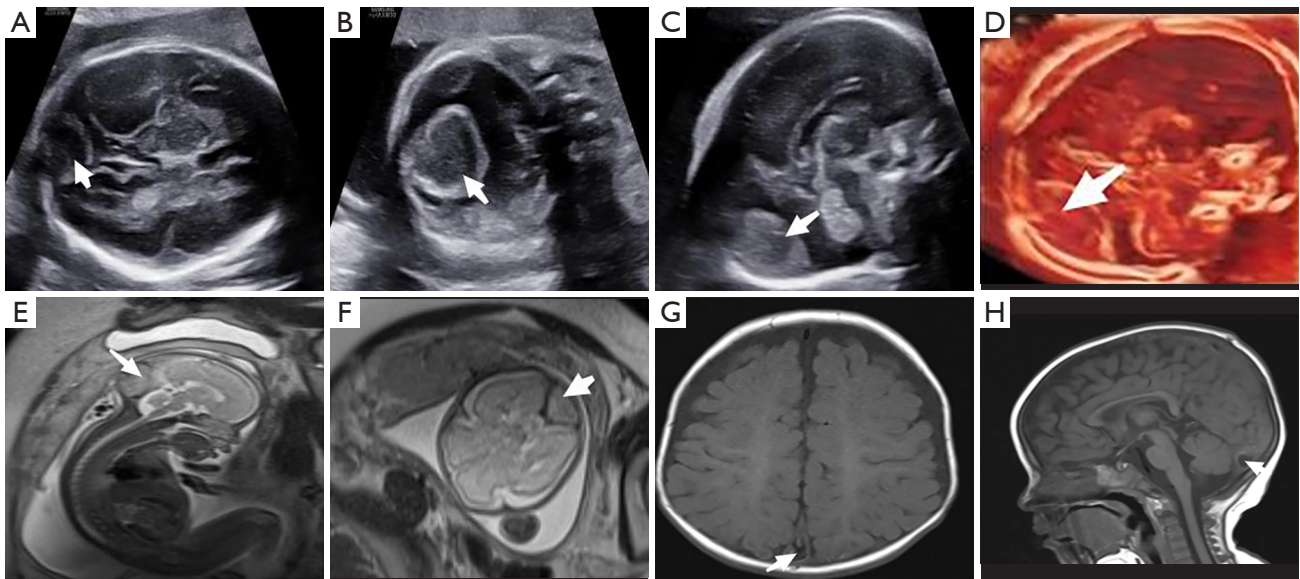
Prenatal ultrasound and prenatal and postnatal MRI images. (A) 2D ultrasound transverse view of the brain shows cystic anechoic at the confluence of the sinus (white arrow). (B) Sagittal view of the skull shows fetal sagittal sinus widening and its internal thrombus (white arrow). (C) Coronal view of the brain shows the thrombus at the confluence of the sinus (white arrow). (D) 3D crystal imaging shows thrombus (white arrow). (E,F) Postnatal MRI T1WI, T2WI images show the superior sagittal sinus and sinus confluence widening, thrombosis (white arrow). (G,H) Reexamination of MRI in July (T1WI, T2WI) localized abnormal signal in sinus confluence area (white arrow). 2D, 2-dimensional; 3D, 3-dimensional; MRI, magnetic resonance imaging; T1WI, T1-weighted imaging; T2WI, T2-weighted imaging.
